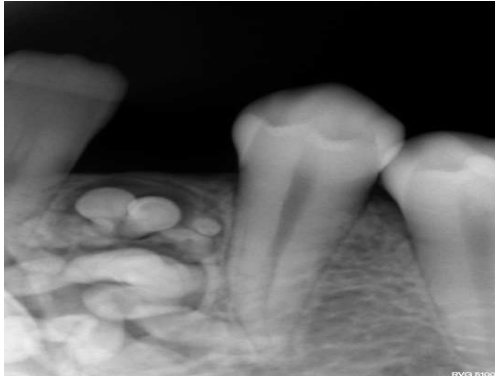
Radiograph showing multiple small teeth like radio-opaque structures.
